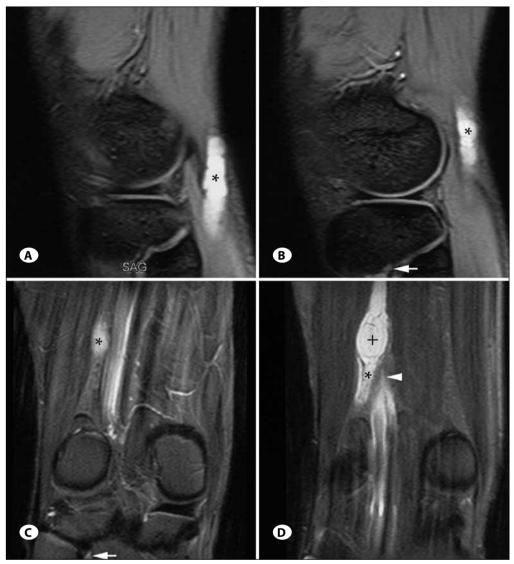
MRIs of the extreme peroneal intraneural ganglion cyst. A) Sagittal T2-weighted gradient echo MR image. This is the most lateral sagittal image in this series. The joint connection is visualized but largely obscured by the overlying markings on the film (SAG). The peroneal intraneural cyst is seen on this image (asterisk). B) Sagittal T2-weighted gradient echo MR image just medial to A demonstrating the peroneal intraneural cyst (asterisk) and its joint connection to the intraneural cyst at the superior tibiofibular joint (arrow) at the very edge of the image. C) Coronal short tau inversion recovery (STIR) image shows the peroneal intraneural cyst in the distal thigh (asterisk) as well as a small amount of fluid in the superior tibiofibular joint at the origin of the intraneural cyst (arrow). D) Coronal STIR image of the distal thigh and knee showing the intraneural cyst in the distal sciatic (plus sign) and common peroneal (asterisk) nerves as well as a small amount of cyst in the proximal portion of the tibial nerve consistent with cross-over and descent.
